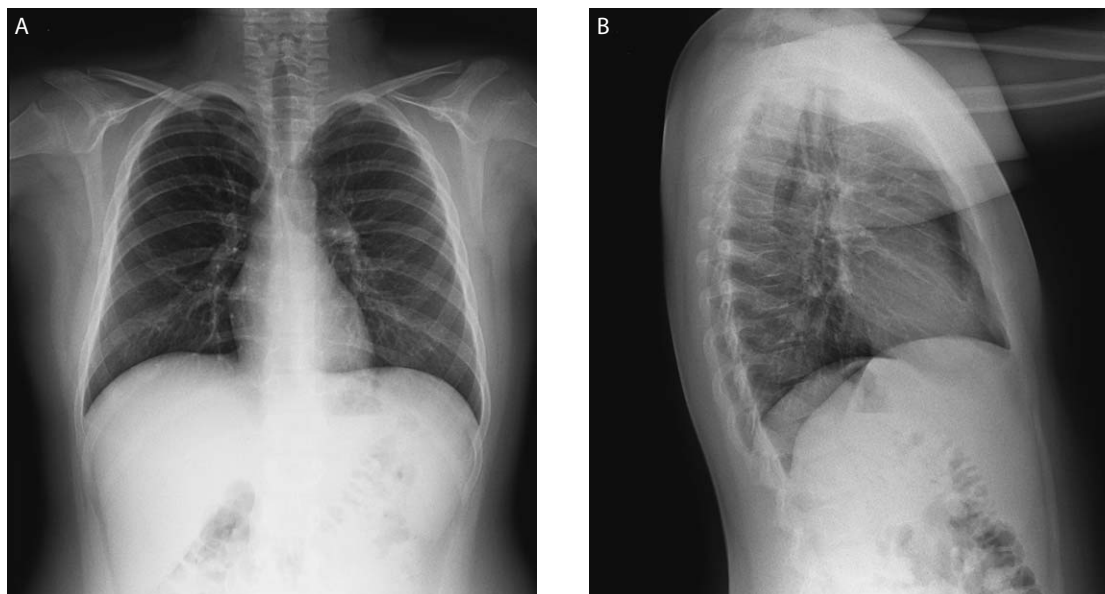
Emergency X-ray of the heart and lungs. Posterior - anterior (A) and lateral (B) chest view which excluded the presence of a foreign body in the airways.
